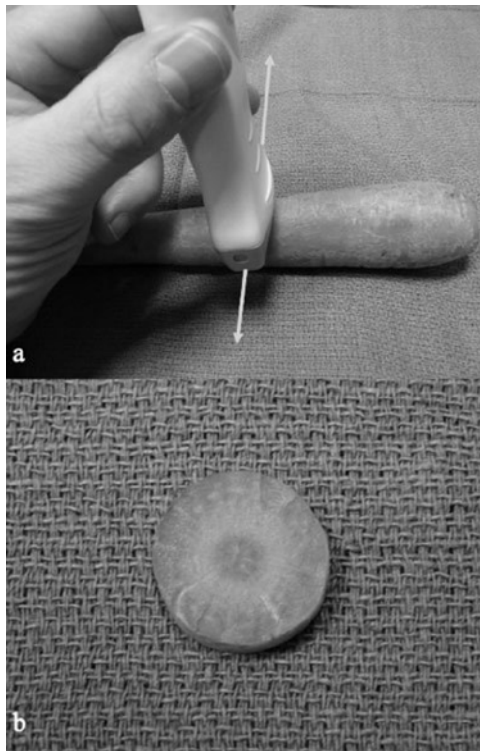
A: Short-axis orientation of the ultrasound probe. B: Resulting image (ie, a transverse “slice” of the structure”).
